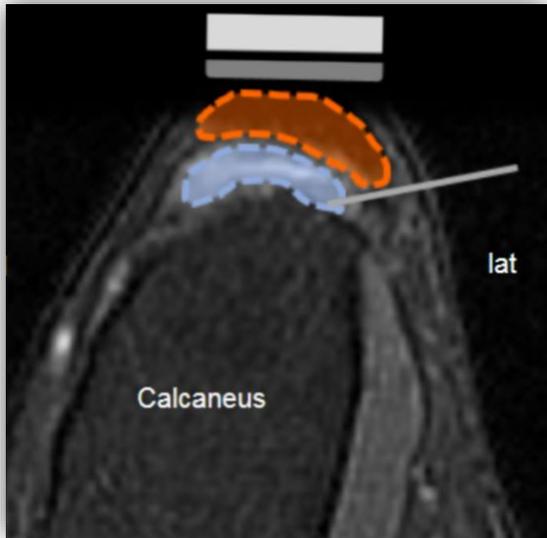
Axial T2-weighted fat-suppressed MR image at the level of the US transducer as seen in Figure 2 depicts the retrocalcaneal bursa (blue) deep to the Achilles tendon (orange). The planned needle trajectory into the bursa is shown from a lateral approach.
